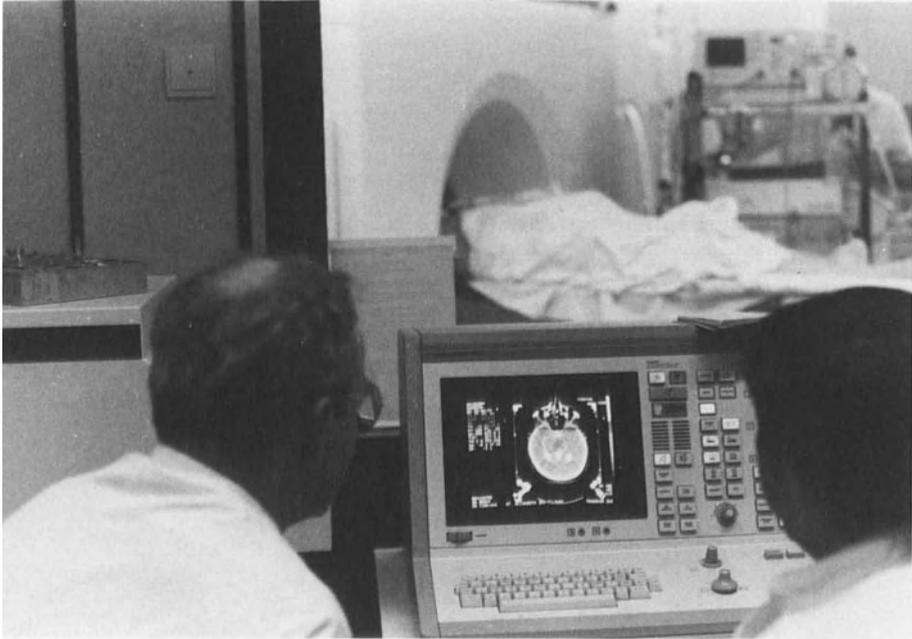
CT scanning with stereotactic instrument fixed to the skull. Positive contrast is seen in the ventricles and around the brainstem for better visualization of the target
